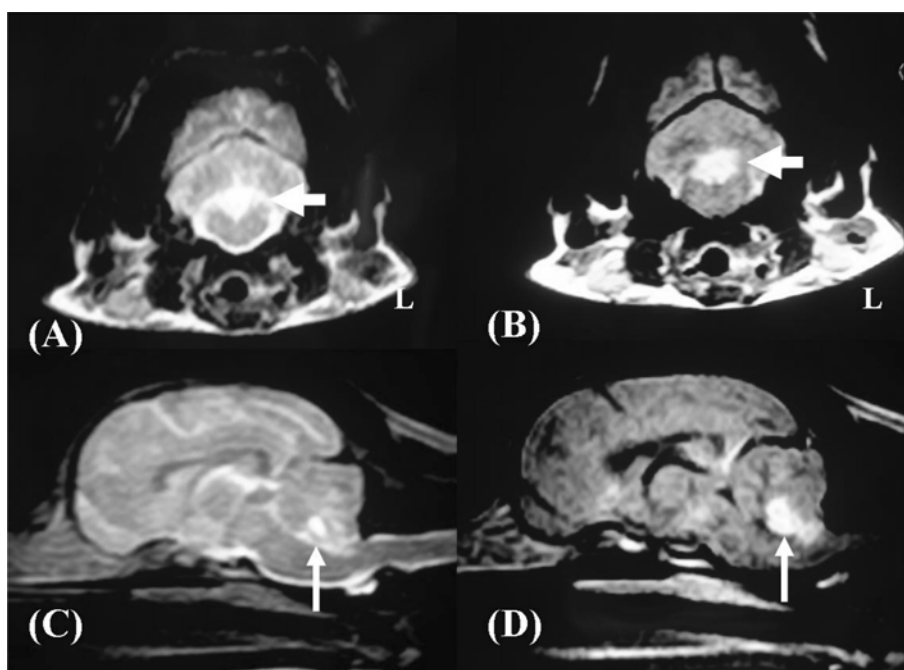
MR images of the present case (A: Transverse T2-weighted image, B: Enhanced transverse T1-weighted image, C: Sagittal T2-weighted image, D: Enhanced sagittal T1-weighted image.). Hypersignal intensified lesion was found at flocculonodular lobe of cerebellum on T2- and enhanced T1-weighted images (arrows).
